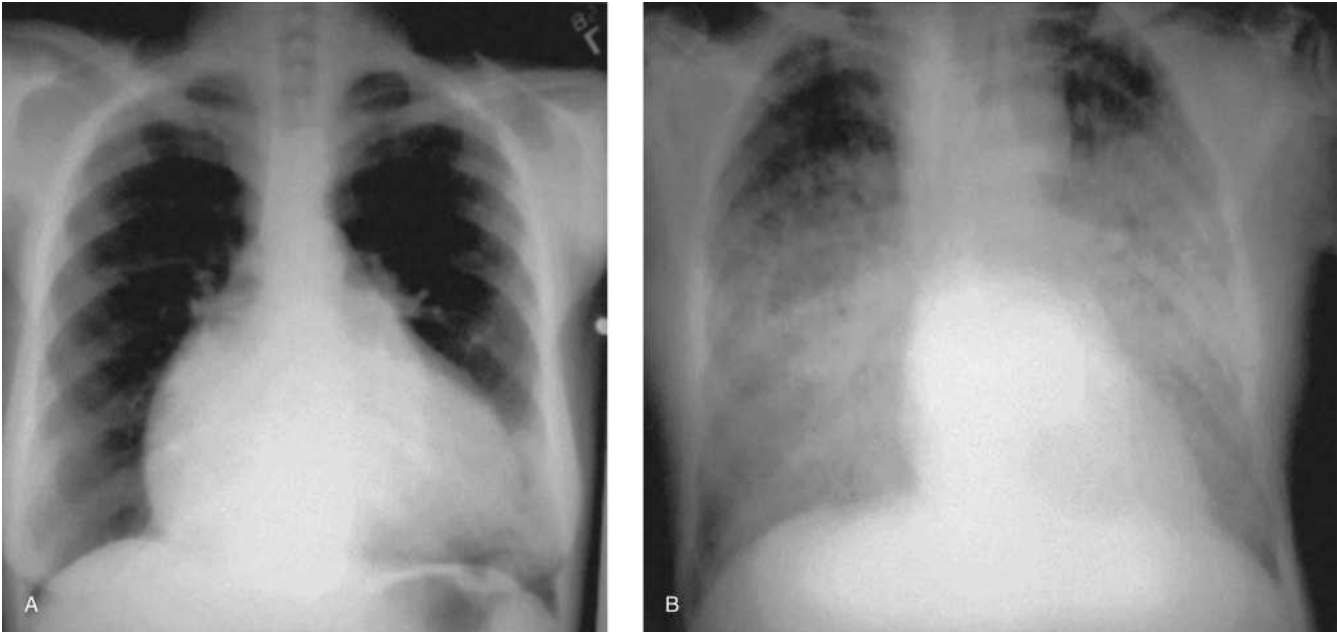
Chest X-ray findings in pericarditis and myocarditis. (A) Cardiomegaly from pericardial effusion. (B) Acute pulmonary edema in myocarditis.
